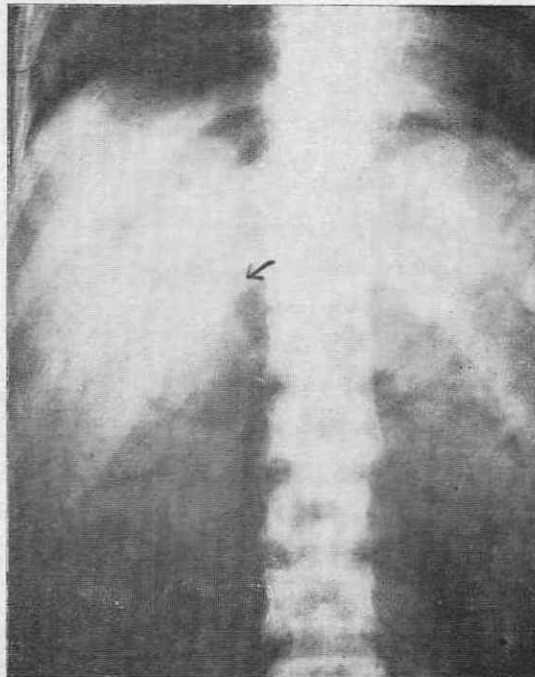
X-ray of the abdomen showing air in the portal vein and its branches.
